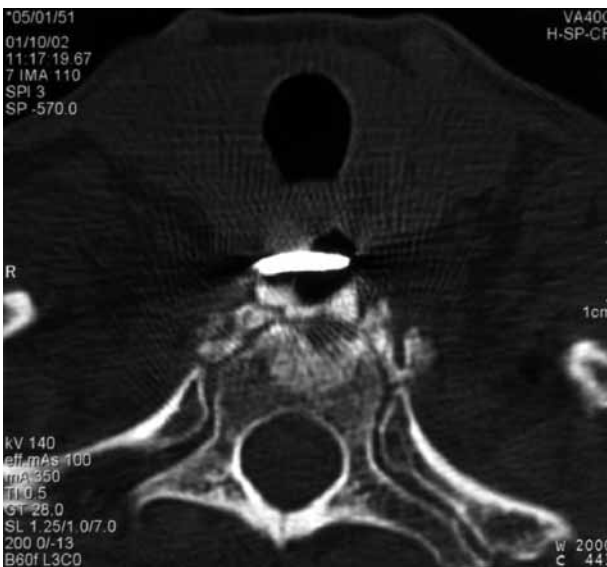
CT scan of the cervical region. Axial view shows the metallic orthopaedic device inside the oesophageal lumen.
